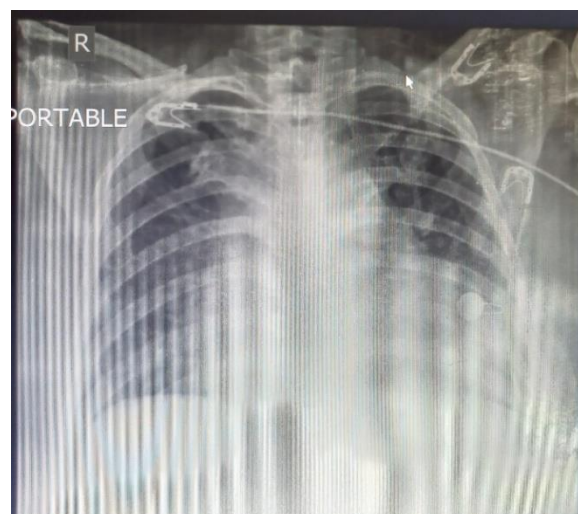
Initial chest X-ray demonstrated an enlarged cardiac index of 0.6, with clear lung fields
